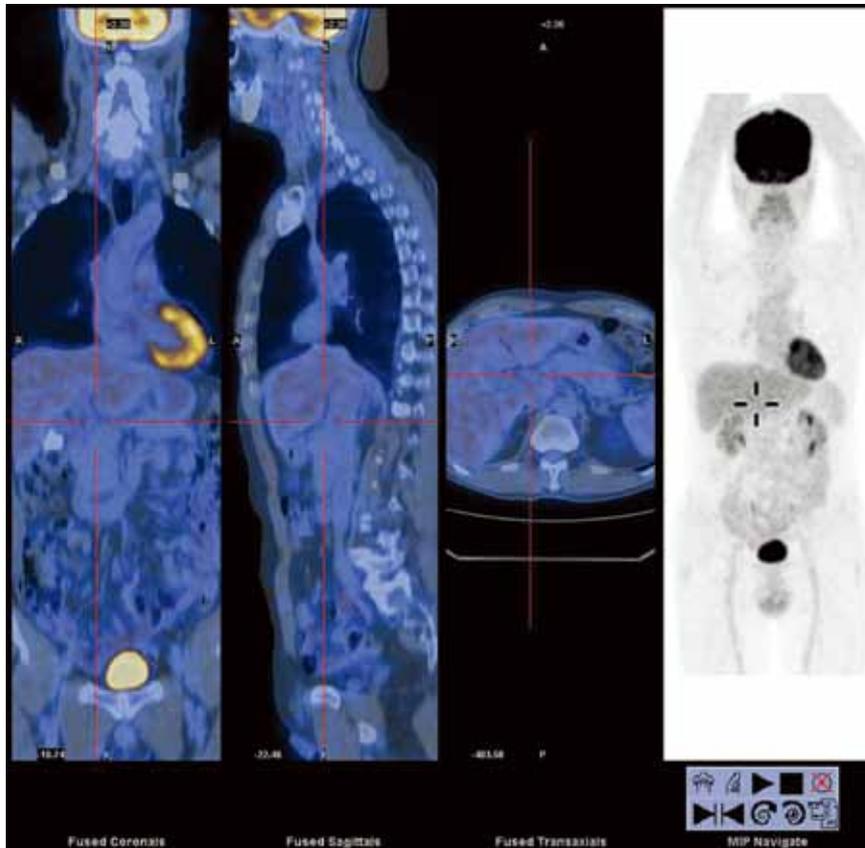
Follow-up positron emission tomography-computed tomography shows hypermetabolic lymphadenopathy and bilateral submandibular masses demonstrating considerable metabolic improvement. The previously noted hypermetabolic enlarged porta-hepatis lymph node demonstrates complete metabolic remission.
